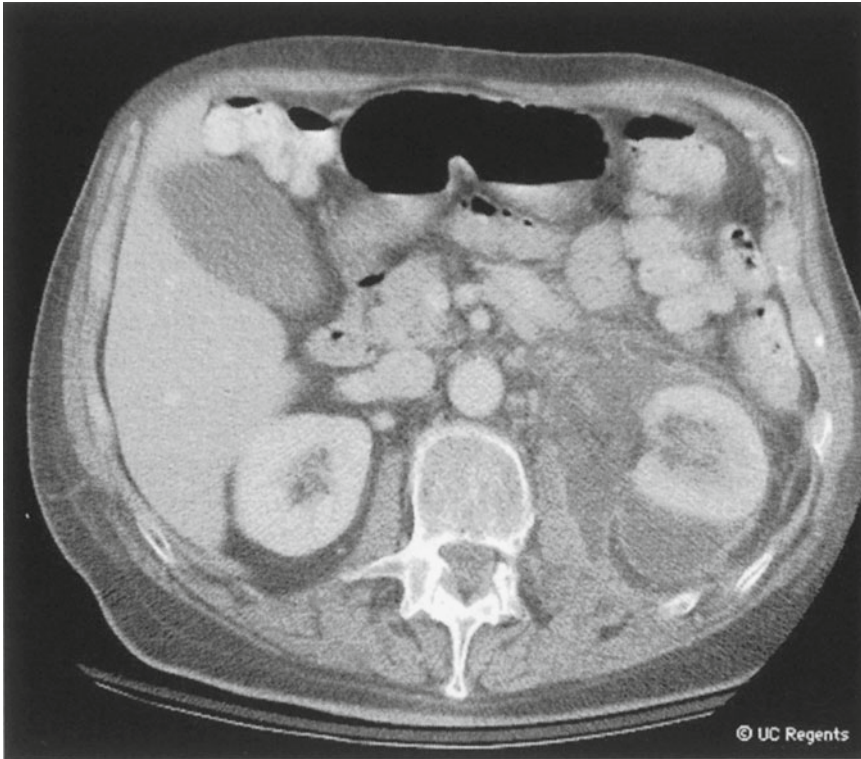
CT demonstrating perinephric abscess around the left kidney. Note the pus surrounding the kidney, confined within Gerota' fascia, and normal appearance of the renal parenchyma
